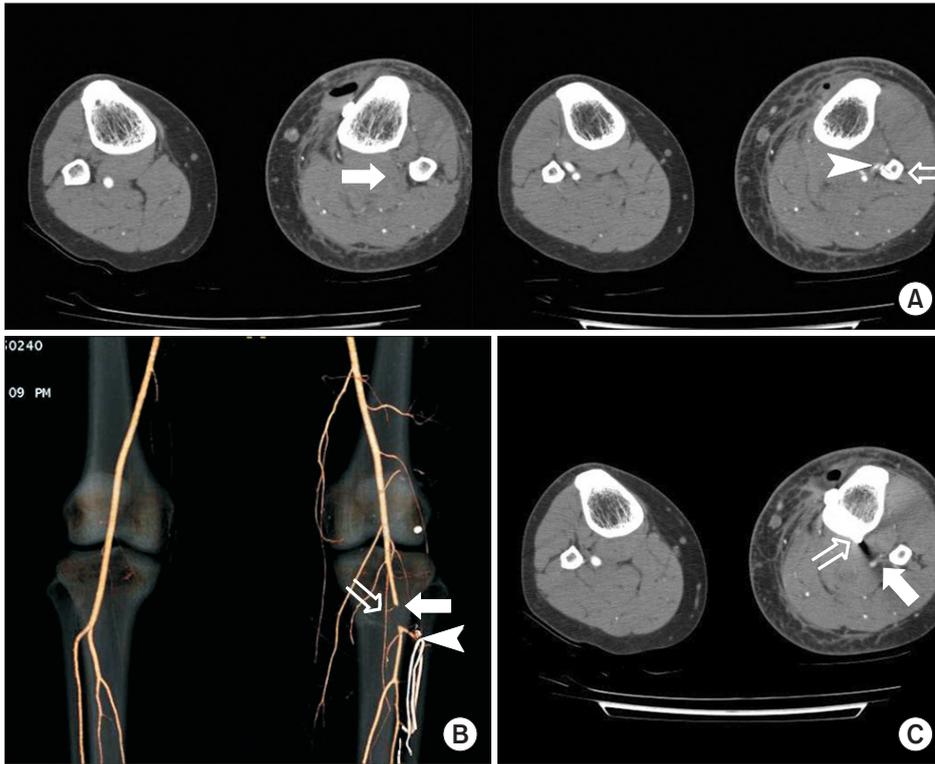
Postoperative computed tomography (CT) and angiogram images. (A) The axial CT images show total occlusion of the left popliteal artery (arrow) and nonvisualization of the left anterior tibial artery (arrow head) with a trace of drilling in the fibula (open arrow). (B) The screw tip (open arrow) is placed 1 cm distal to the popliteal occlusion site (arrow) and 5 mm proximal to the root of the anterior tibial artery (arrow head). (C) On the axial CT image, the screw tip (open arrow) is 15 mm away from the anterior tibial artery (arrow).
